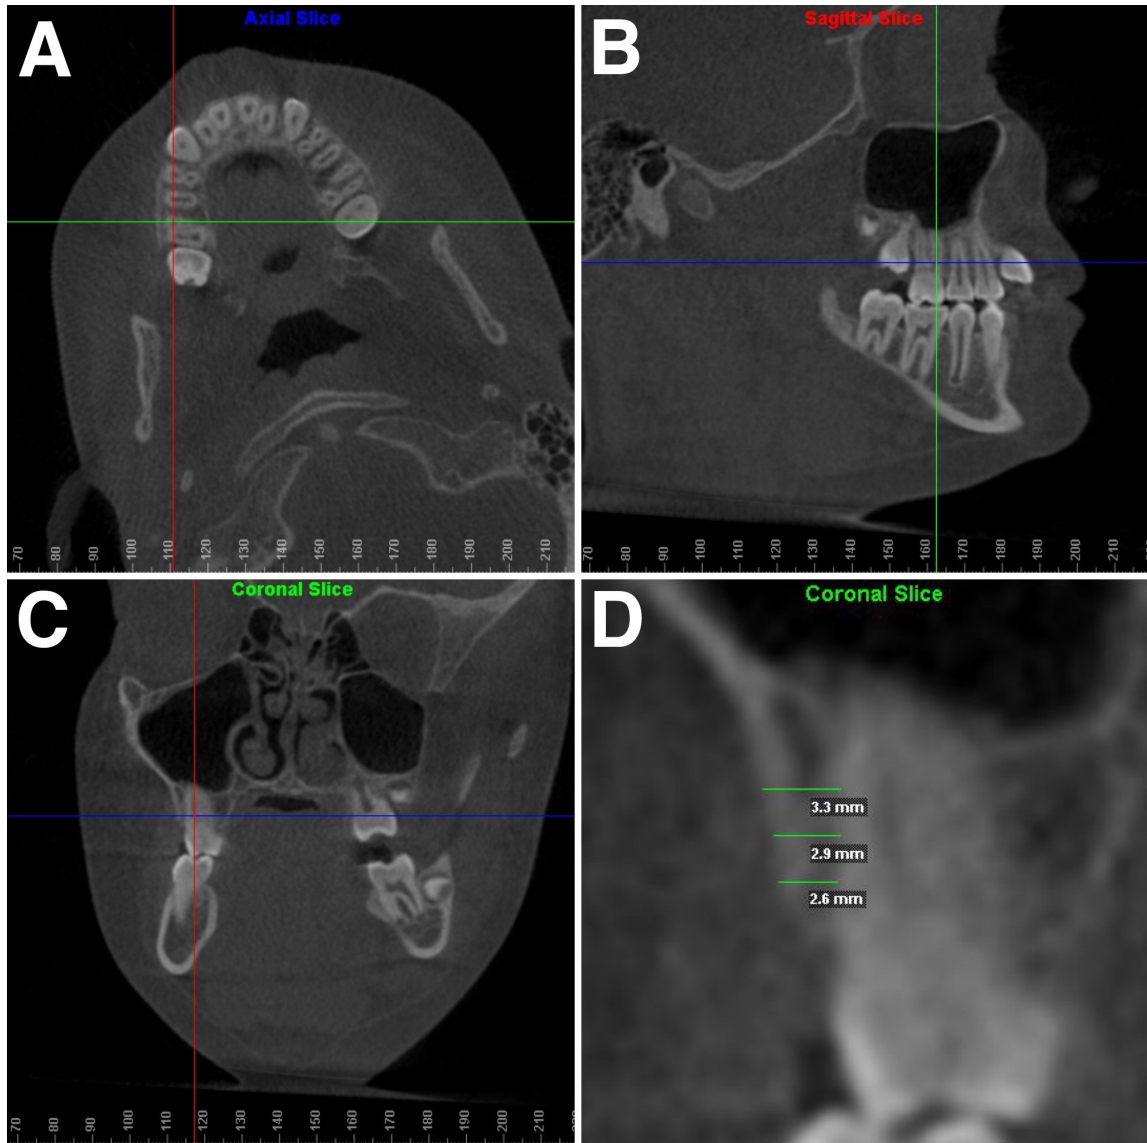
Orientation and measurement of CBCT slices using Dolphin Imaging software: A, axial orientation; B, sagittal orientation; C, coronal orientation; D, magnified coronal section and buccal alveolar bone measurements at B4, B6, and B8.
